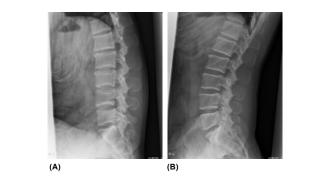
Lateral radiographs of the spine in flexion (A) and extension (B) showed no abnormality.
